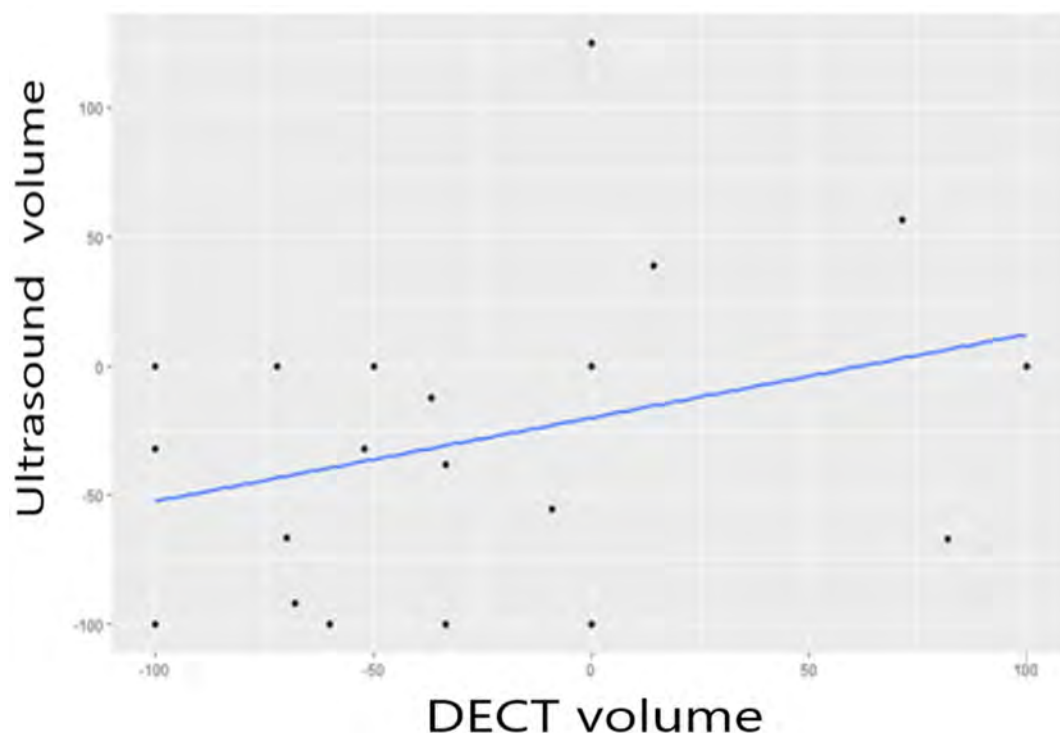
Evolution (in % from baseline) at month 6 of the index tophus measured with dual-energy computed tomography (DECT) and ultrasound.
